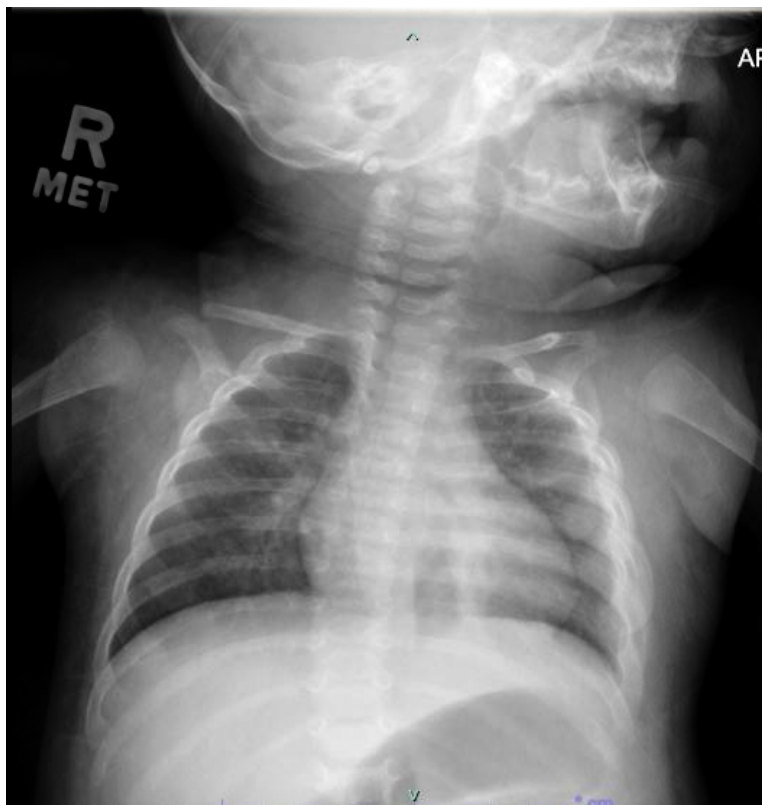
Chest x-ray with abnormal appearance of multiple left ribs with probable periosteal/cortical thickening and asymmetric soft tissue thickening.
